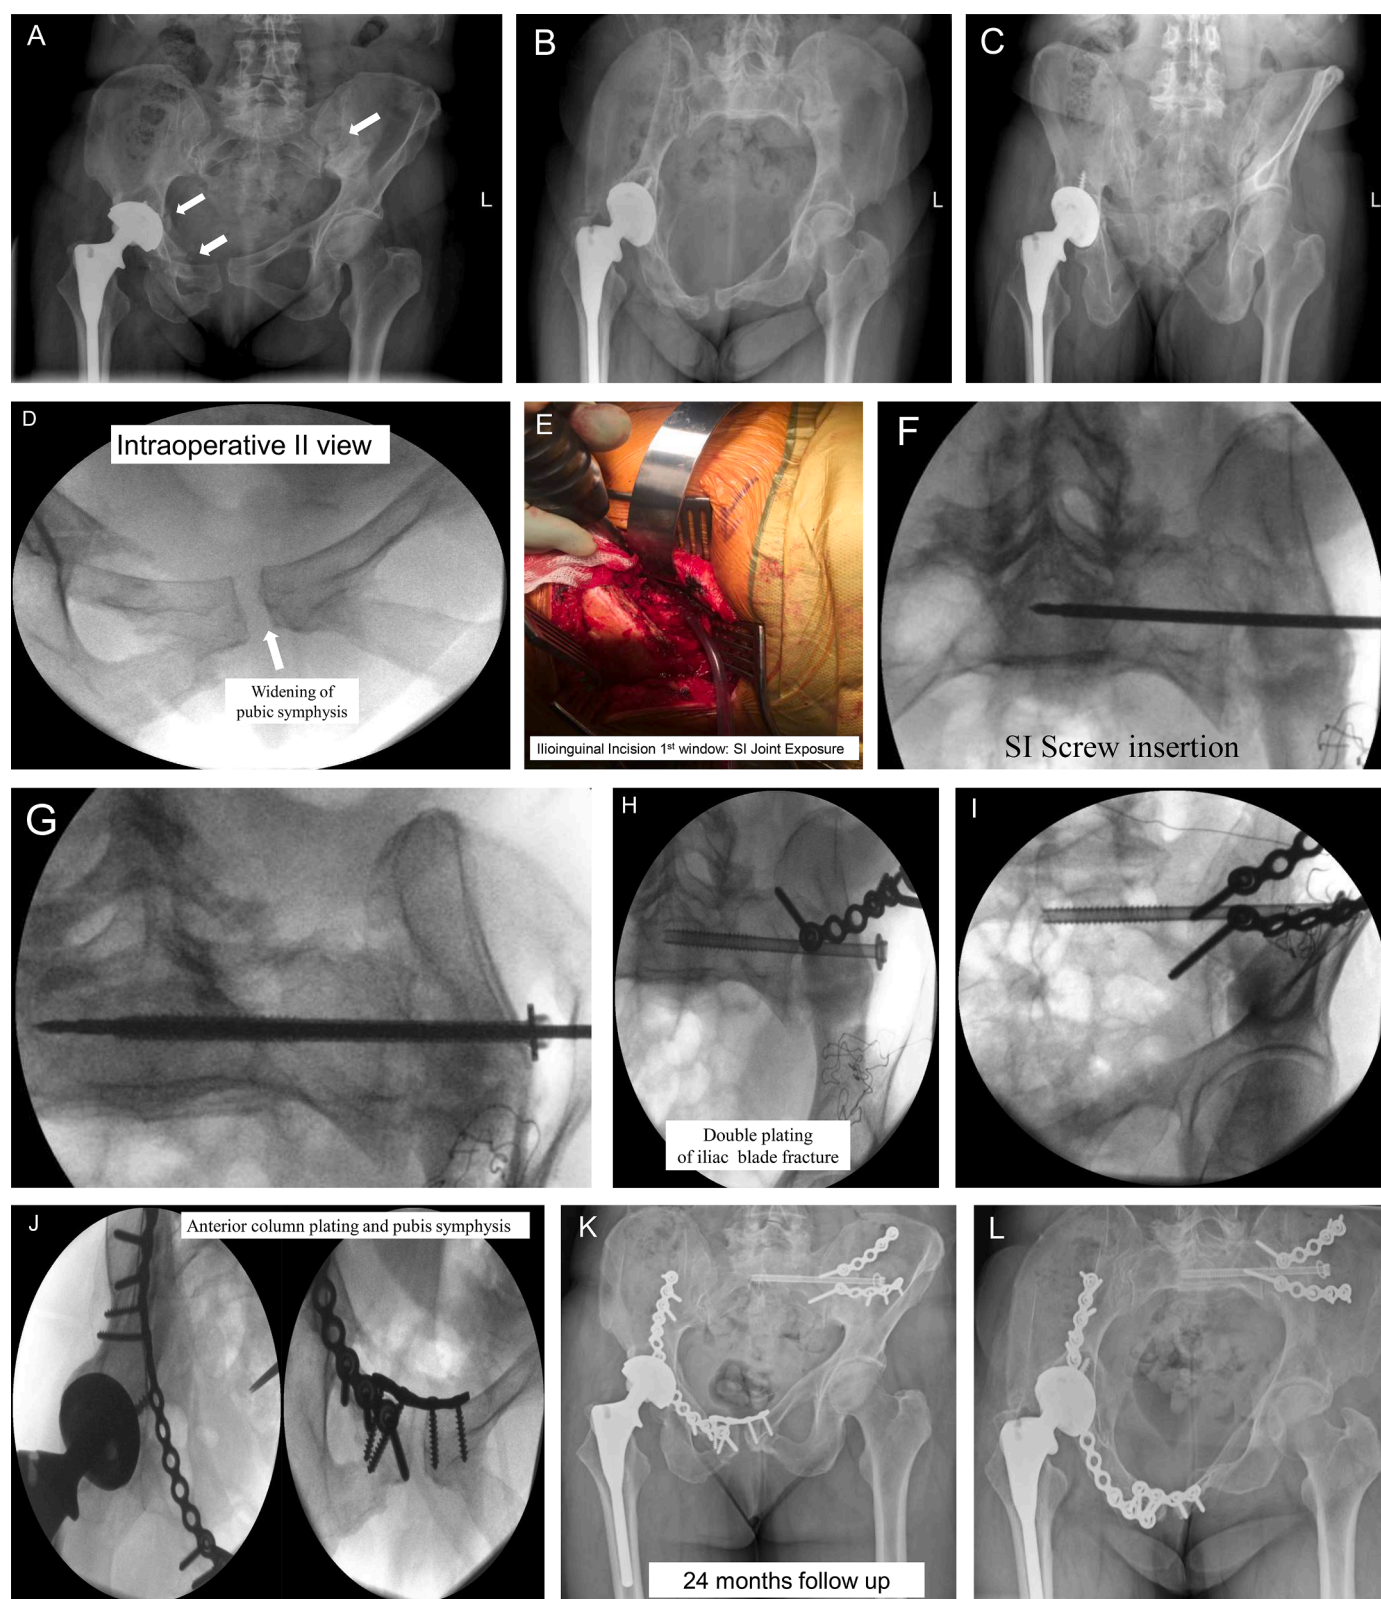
Anteroposterior (1A), inlet (1B) and outlet (1C) radiographs demonstrating delayed presentation of a complex right periprosthetic fracture in a 58-year-old female patient with disruption of the pelvic ring sustained following a mechanical fall (white arrows). Evidence of instability was clinically apparent as demonstrated using intraoperative image intensifier (II) (1D). Surgical stabilization involved sacroiliac (SI) joint exposure and screw fixation (1E, 1F, 1 G), double plating of the iliac wing fracture (1H, 1I), anterior column plate fixation and stabilization of the pubic symphysis (1 J). Postoperative radiographs at 2-years demonstrate satisfactory union and no migration of the acetabular shell on anteroposterior (1 K), inlet (1 L) and outlet radiographs (1 M).
